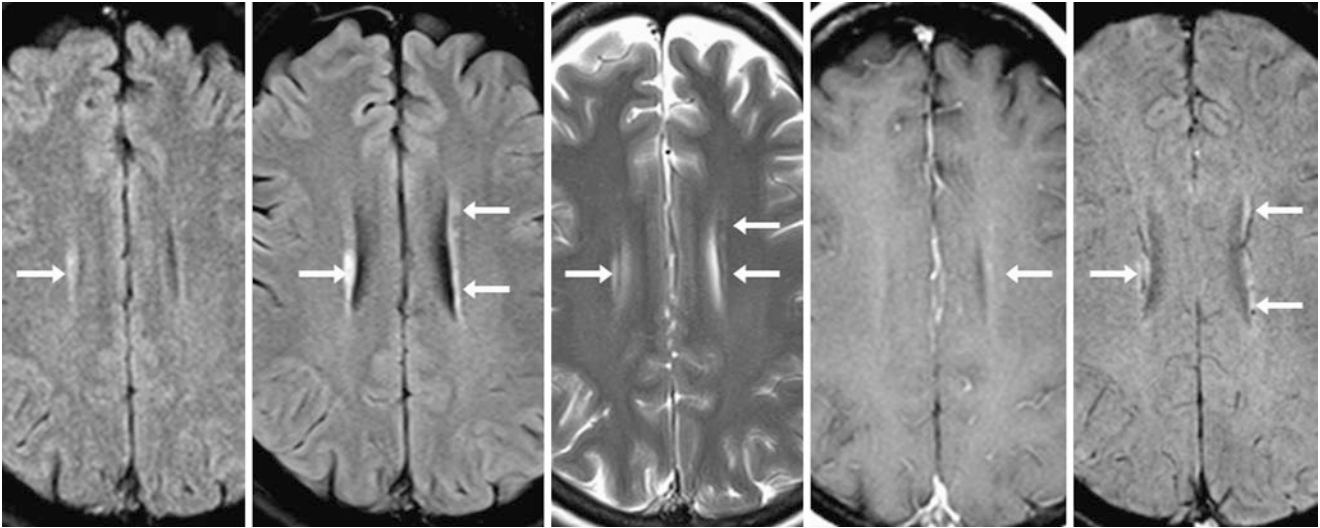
A 52 year old with a right-sided PEP (*arrows*) seen on axial FLAIR MRI (*left*). It became more discernible and likely worsened because a left-sided PEP had developed as well on a FLAIR MRI 2 years later (*left middle*) and on T2WI (*middle*). Postcontrast T1WI
